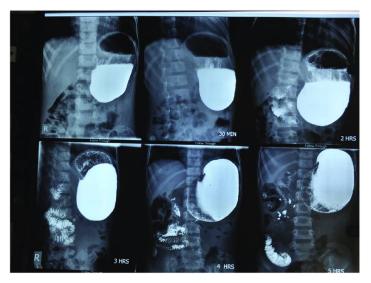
11 Barium meal X-RAY
